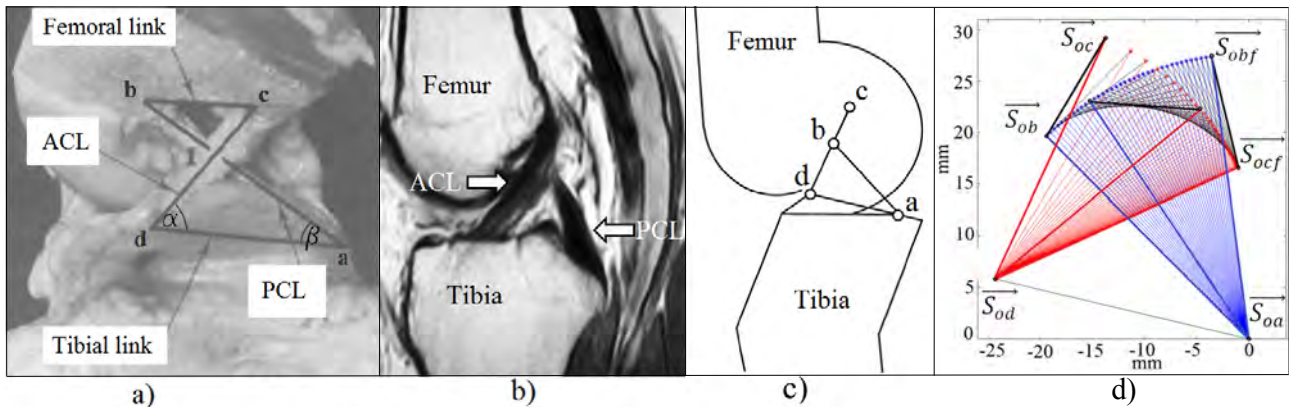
a) Knee in flexion with a cross four-bar mechanism superimposed on the cruciate ligaments (O'Connor *et al.*, 1989). b) MRI of a knee in extension (Lykissas *et al.*, 2010). c) Physical model of the knee in extension (O'Connor *et al.*, 1989). d) Successive positions of the cruciate ligaments: ACL in red, LCP in blue, tibial and femoral link in black.
